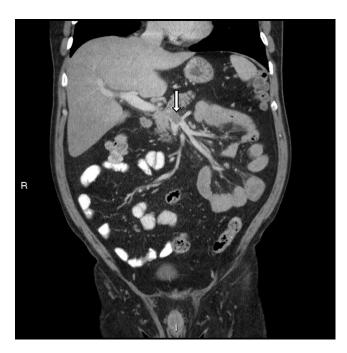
Coronal reformat of a computed tomography (CT) of the abdomen with intravenous and oral contrast, in the portal venous phase. Thrombosis can be seen at the confluence of the superior and inferior mesenteric veins (shown by the arrow).
